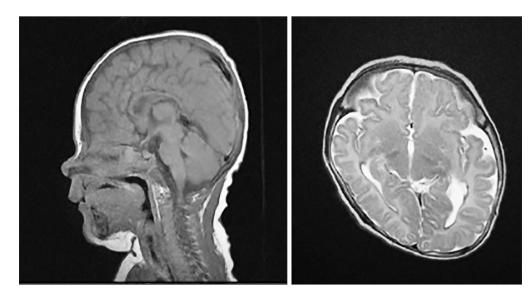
Control cranial MR imaging on day 133.
